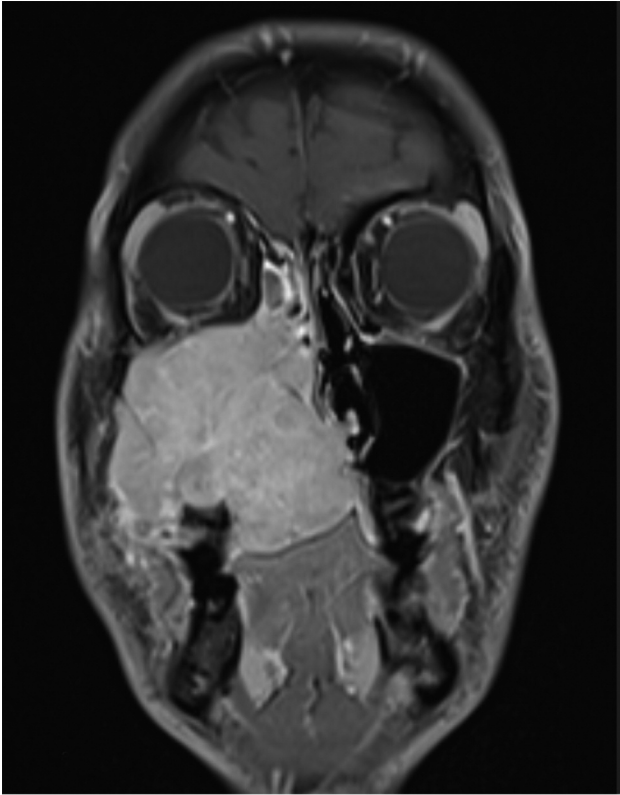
Preoperative magnetic resonance imaging (MRI) – Coronal view. T1-weighted MRI of a coronal section showing an inhomogeneous, contrast medium-enhancing solid mass in the area of the right maxillary sinus with contralateral midline crossing as well as infiltration of the ethmoid cells and displacement of the nasal septum.
